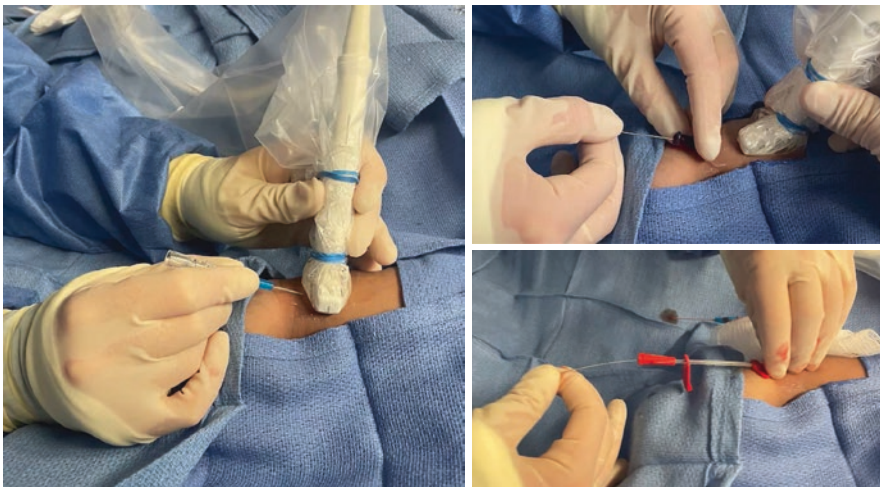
Arterial line placement technique under ultrasound guidance
